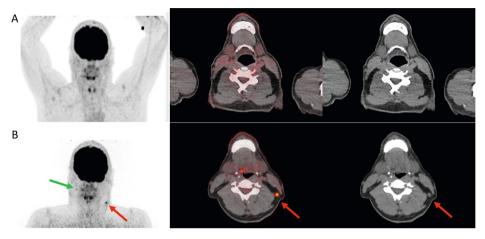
[18F]FDG PET/CT of a patient with recurrence in cohort 2: stage IIIC melanoma of the scalp. [18F]FDG PET/CT before reexcision and sentinel lymph node procedure (A), with no signs of metastases in head/neck region or elsewhere in the body (not shown). [18F]FDG PET/CT before adjuvant therapy after surgery (B). [18F]FDG-avid lymph nodes were found in level IIb in the left neck (red arrow) and level Vb (green arrow), which after cytologic puncture appeared melanoma metastases.
